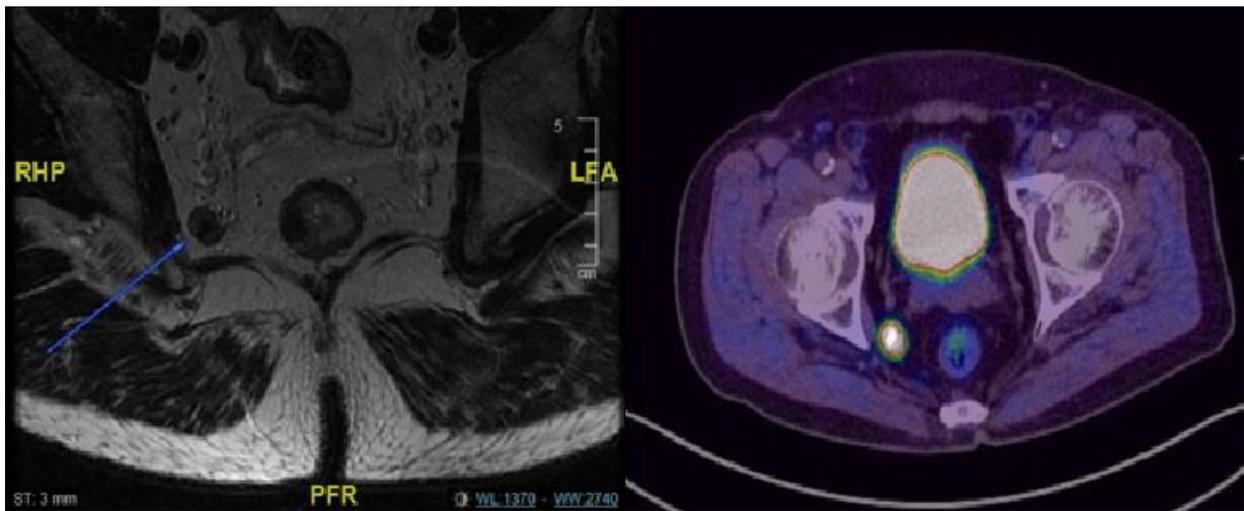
Metastatic lateral pelvic lymph node seen on MRI rectum and PET scan.
